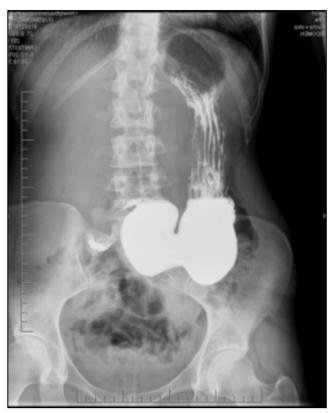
X-ray passage with a barium contrast - the stomach ptosis extending to the area of the small pelvis
